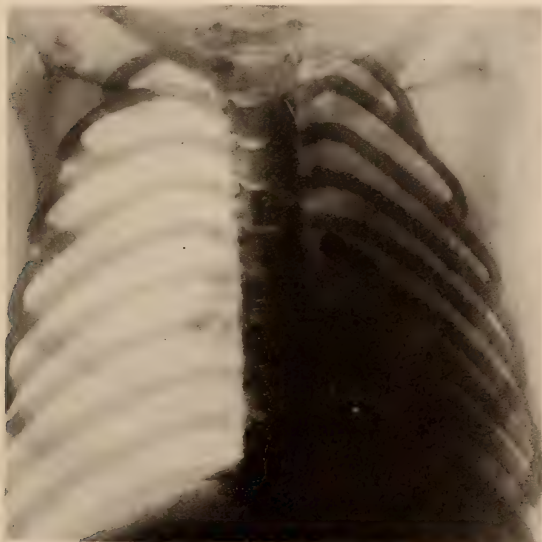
Roentgenogram showing bullet in left bronchus.
